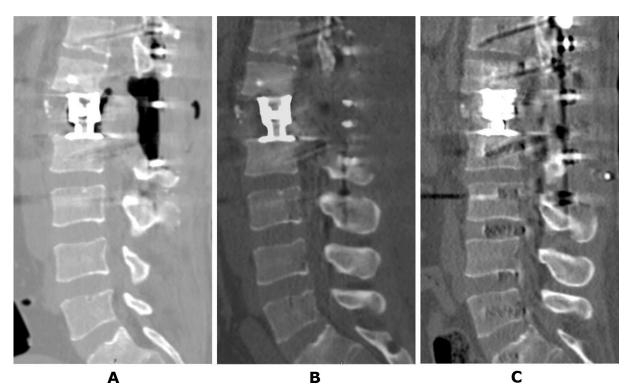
Patient T., 41 years old. CT scan of the lumbar spine: A - 3 days after surgery; B - 2 months later; C - 6 months later (details provided in the text)
